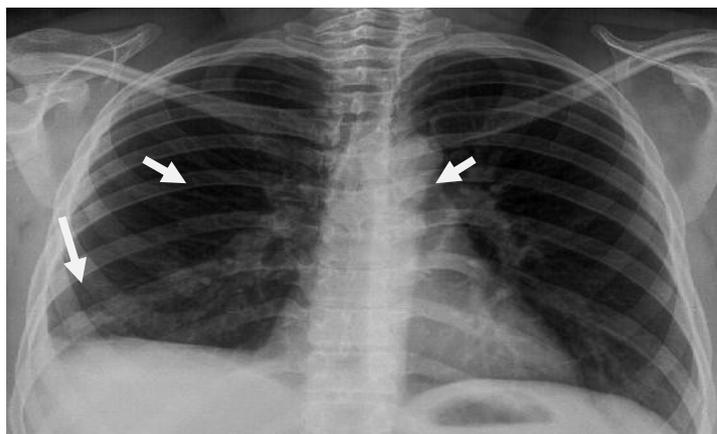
Plain chest x-ray (antero-posterior view) showing right basal pneumonic infiltration with bilateral increased bronchovascular markings.
